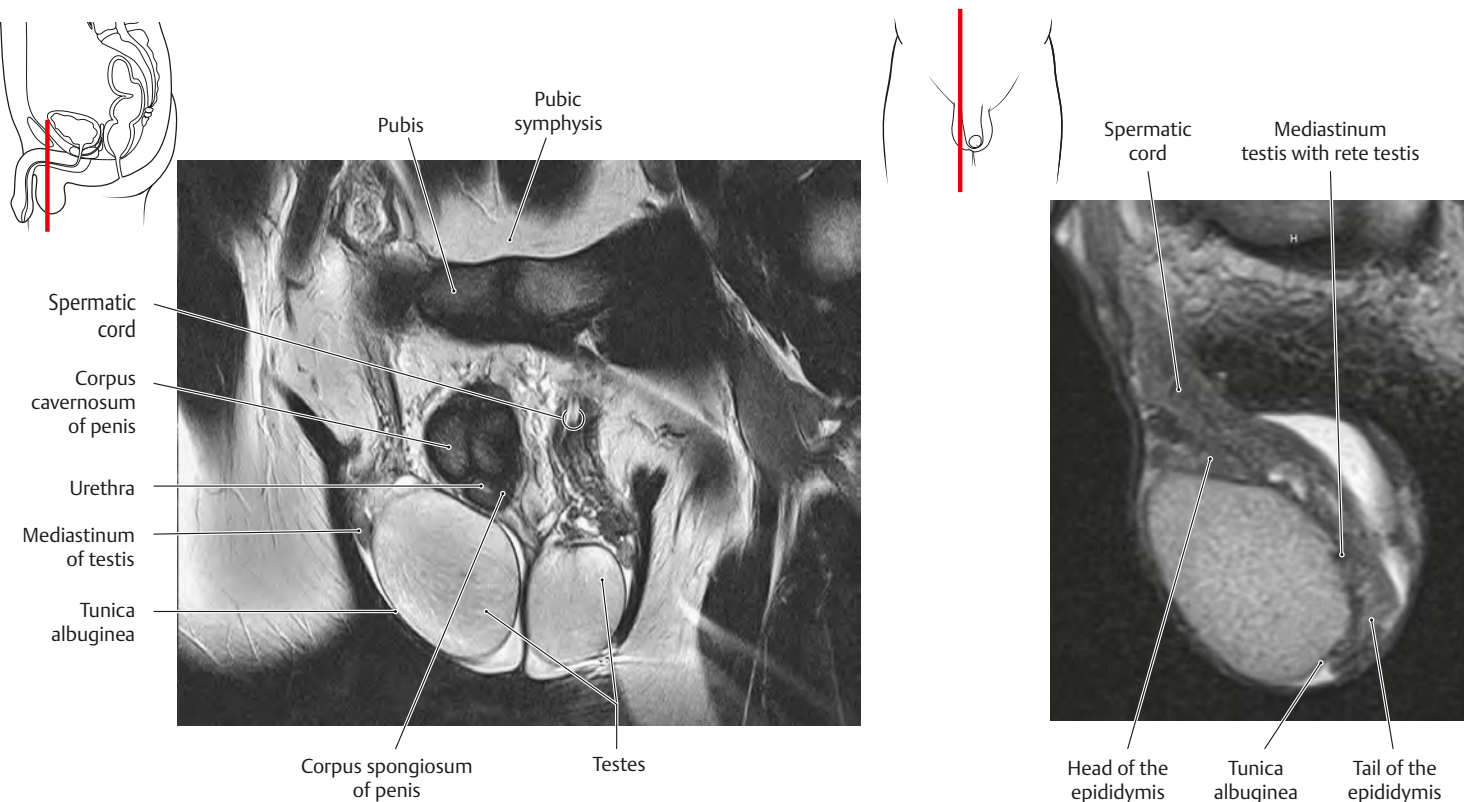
MRI of the testes
